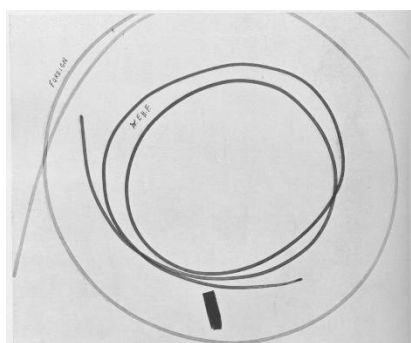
A ‘Comparison radiograph of shadowgraph bougies for ureteric examination.’ From Hurry Fenwick (1908). The densely opaque bougie labeled EHF is markedly superior to the foreign product.
